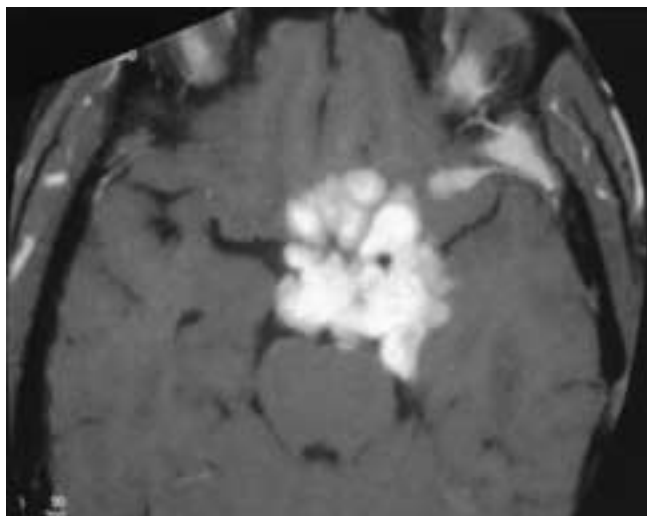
Leptomeningeal sarcoidosis presenting as a mass in a 45-year-old female with encasement of the chiasm and optic nerves. T1-weighted axial, fat-suppressed image after gadolinium injection. Except for the nodularity of the mass, its appearance mimicked a meningioma of the lesser wing of the sphenoid.
